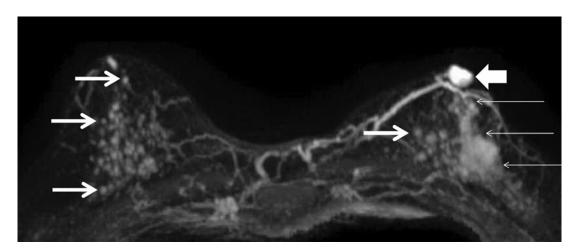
A 54-year-old woman, with biopsy-proven ductal carcinoma in situ (DCIS) in her left breast, who underwent preoperative breast magnetic resonance imaging, demonstrating nonmasslike enhancement in her left breast (long thin arrows) that extended from the chest wall to behind the nipple; a mammographically occult mass in the same breast (short thick arrow) in the retroareolar region; and multiple, enhancing foci in both breasts (white arrows). Left breast ultrasound-guided biopsy confirmed that the retroareolar left breast mass was a 1.2-cm invasive ductal cancer, and the foci in the left breast at mastectomy were benign proliferative changes, the extent of DCIS correlated with the nonmass enhancement.
